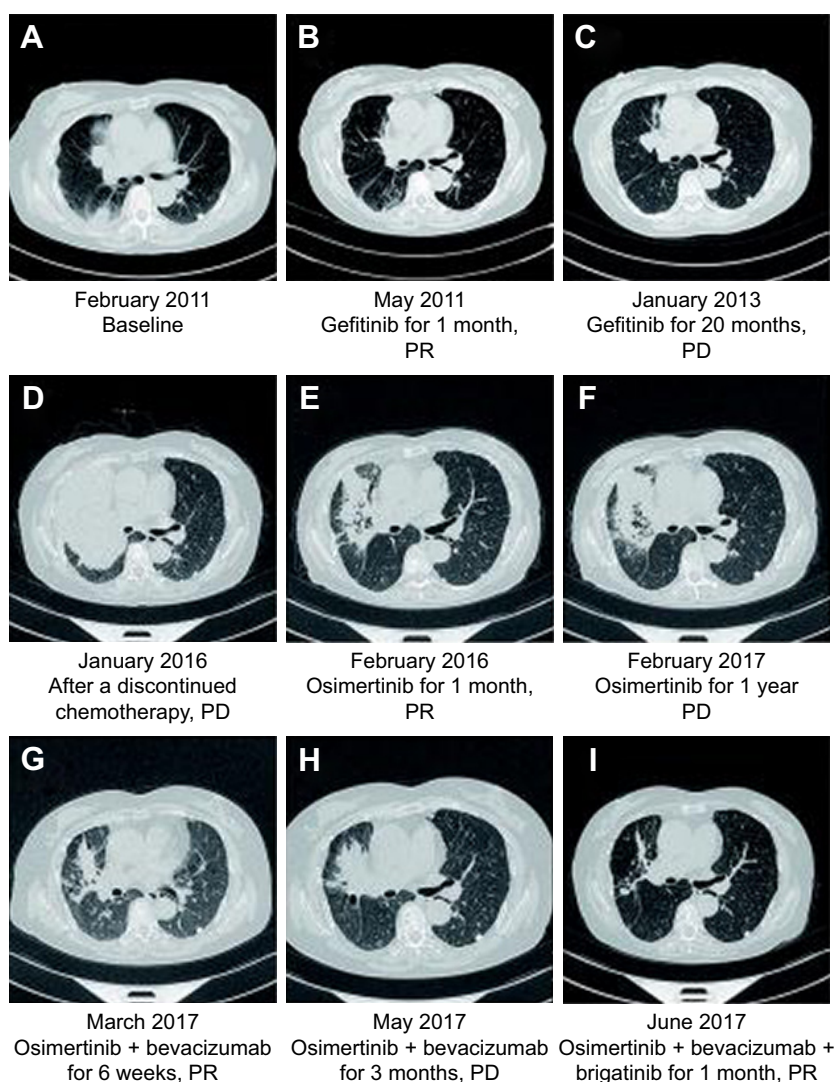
(A–I) Chest CT scans at various time points.
